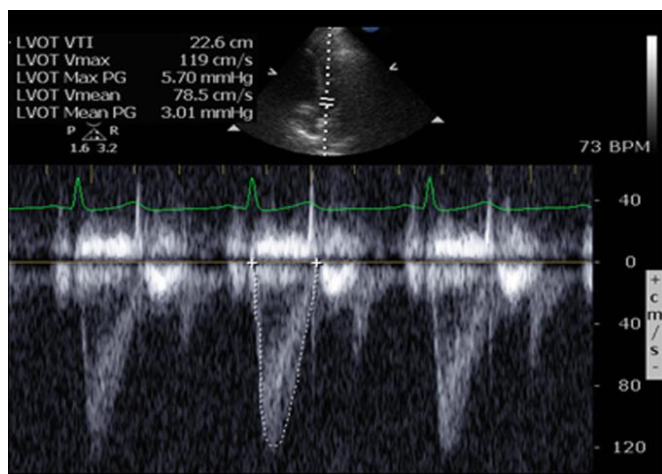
Measurement of velocity-time integral tracing by pulse wave Doppler in the left ventricular outflow tract
